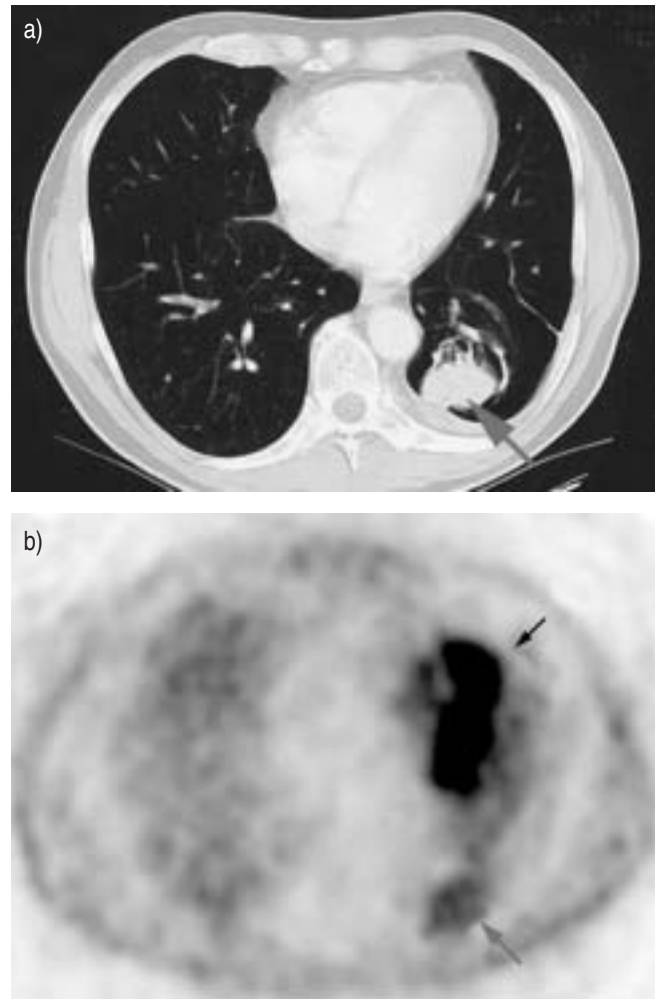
A 47-yr-old patient with rounded atelectasis. a) Computed tomography scan showed pleural plaques and rounded atelectasis (grey arrow). b) Transverse ^{18}F -fluorodeoxyglucose (^{18}F FDG) imaging via coincidence detection emission tomography identified a moderate increased of ^{18}F FDG uptake in rounded atelectasis (grey arrow). There is physiological uptake of ^{18}F FDG by the myocardium (arrow).
